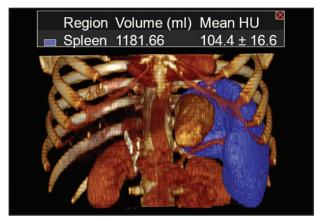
CT volume rendering of the spleen (blue) with measured volume included.
